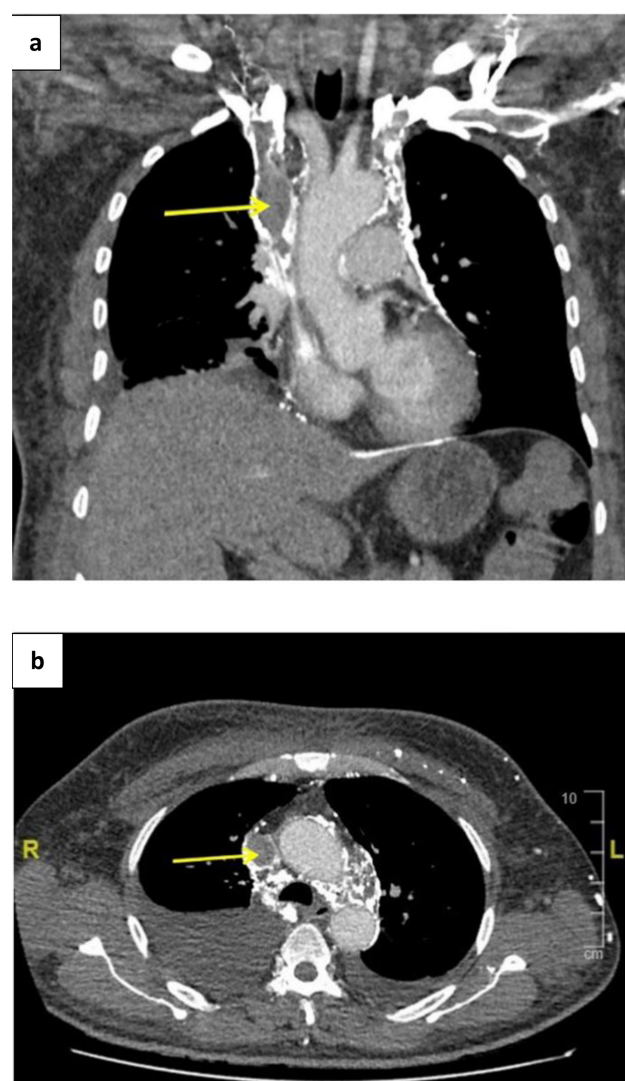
Computed tomography of the thorax. a) Coronal view: yellow arrow showing the thrombus in the superior vena cava. b) Axial view: yellow arrow showing the thrombus in the superior vena cava.
